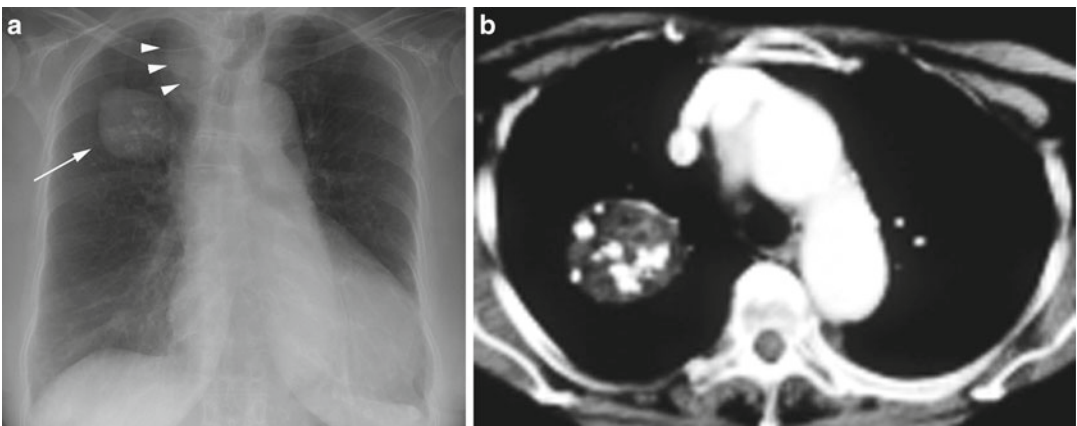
Hamartoma. (a) Frontal chest radiograph reveals a 3 cm well-circumscribed right upper lobe nodule with internal chondroid calcifications (arrow). Note also right
